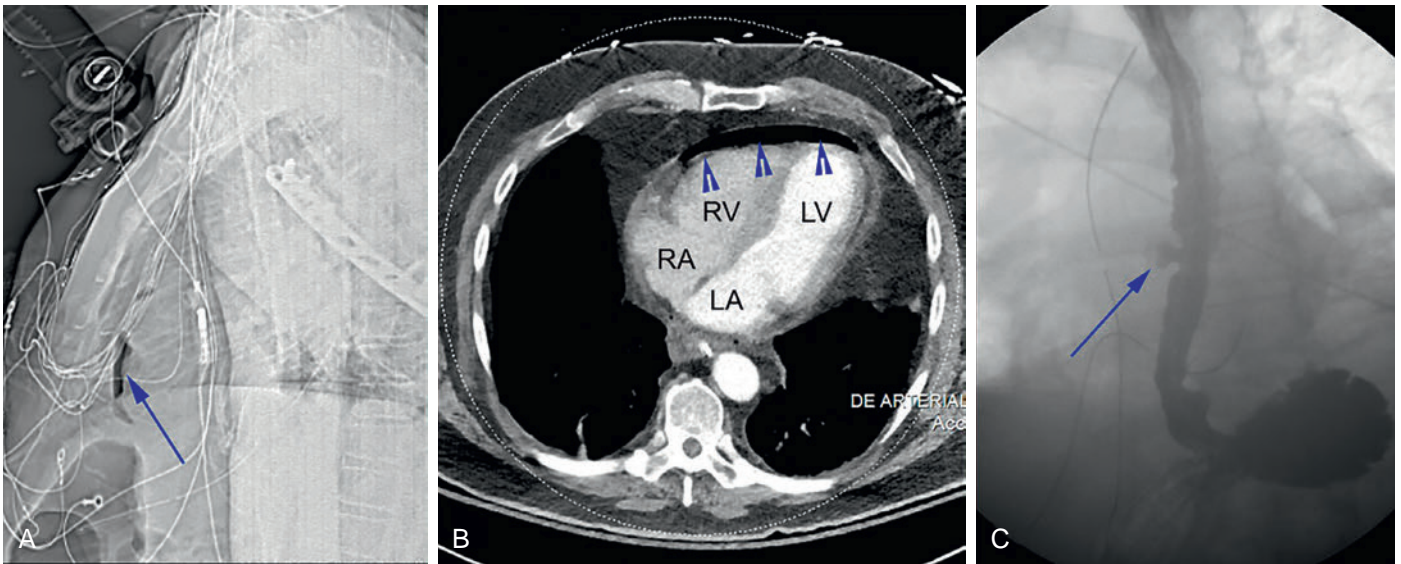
Esophageal-Pericardial Fistula. A 62-year-old patient presented with chest pain 21 days following ablation of atrial fibrillation, and was diagnosed with esophageal-pericardial fistula. (A) Chest x-ray (left lateral projection) obtained in supine position showing air accumulation (arrow) anterior to the cardiac silhouette. (B) Computed tomographic scan showing pneumopericardium (arrowheads). The free air wraps around the anterior right ventricle (RV) extending across the apex of the left ventricle (LV). No air is observed within the cardiac chambers. (C) Gastrografin esophagogram showing focal out-pouching from the esophageal wall (arrow) at the junctions of the middle and distal thirds of the esophagus representing local ulceration or sinus tract. LA, Left atrium; RA, right atrium.
